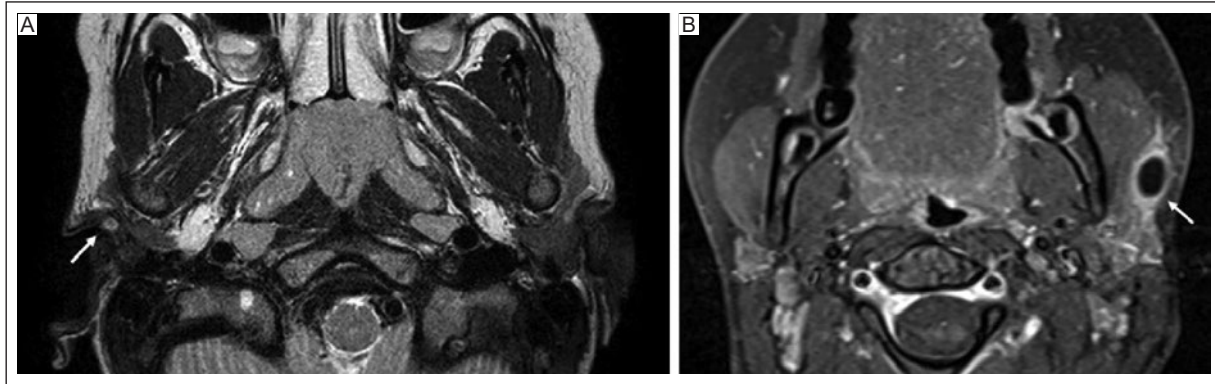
First branchial cleft cyst. A: axial T2-weighted image shows a Work type I first branchial cleft cyst along the external auditory canal (arrow). B: axial post-contrast fat-suppressed T1-weighted image shows a Work type II first branchial cleft cyst (arrow). Notice the central cystic component with peripheral enhancement that may represent mild inflammatory change.
